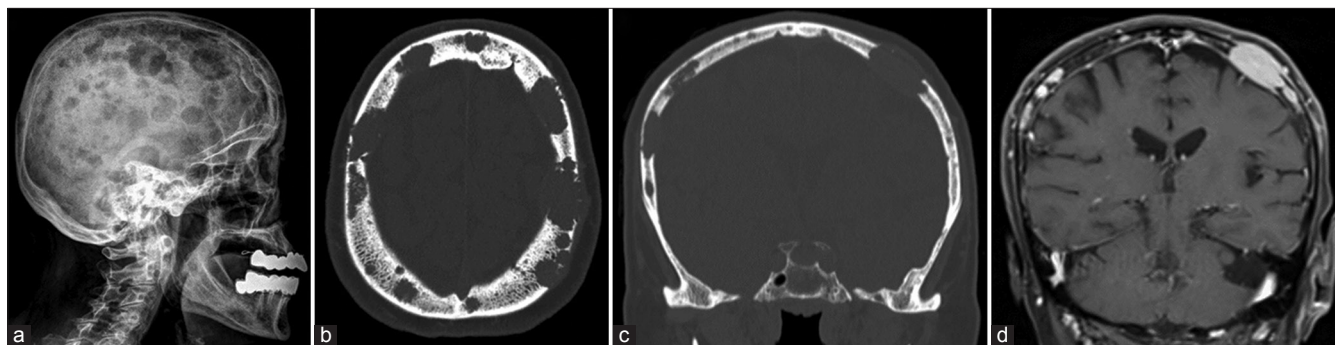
(a) Lateral skull radiograph demonstrating the classic “raindrop skull” appearance. (b and c) Axial and coronal brain computed tomography, “bone window,” shows variable-sized, well-defined osteolytic lesions of the calvarial vault; the largest lesion measures 2.4 cm at the left frontal bone. (d) Coronal brain magnetic resonance imaging with contrast showing subgaleal and epidural soft tissue component enhancement. An incidental left cerebellar arachnoid cyst is noted. The brain parenchyma is unremarkable.
